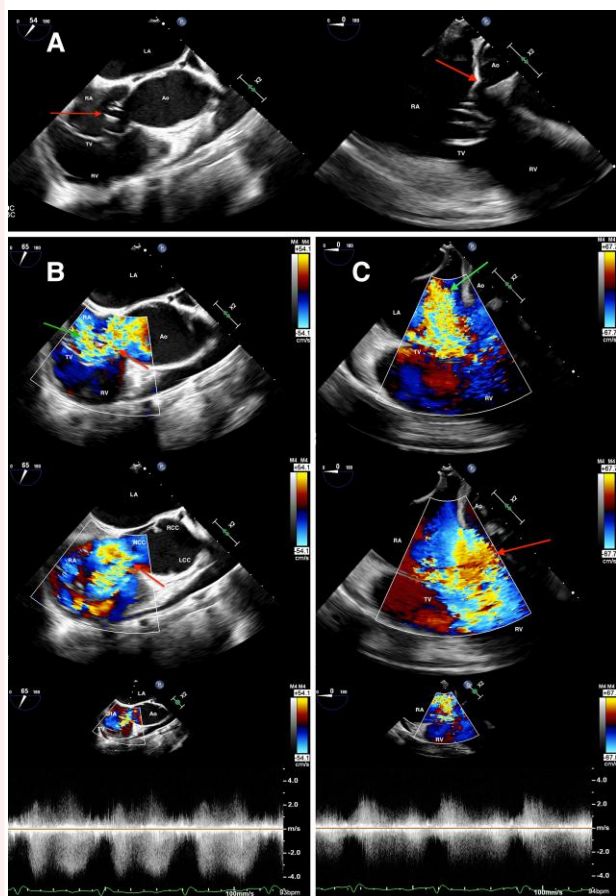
Transoesophageal echocardiographic images. Modified mid-oesophageal aortic valve short-axis view (A, left) and mid-oesophageal five-chamber view (A, right) revealing disruption of the aortic sinus and prolapse of the ‘windsock’ into the tricuspid valve. Modified mid-oesophageal aortic valve short-axis views (B) differentiating two individual systolic jets representing tricuspid regurgitation and ruptured sinus of Valsalva aneurysm flow (top), high-velocity diastolic ruptured sinus of Valsalva aneurysm flow (mid), and Doppler profile describing continuous flow through the ruptured sinus of Valsalva aneurysm (bottom). Mid-oesophageal five-chamber views (C) demonstrating moderate–severe systolic tricuspid regurgitation (top) and high-velocity diastolic ruptured sinus of Valsalva aneurysm flow through the TV (mid). Doppler profile demonstrates continuous forward flow and bidirectional systolic flow through the tricuspid valve (C, bottom). Red arrow, RSOVA and/or RSOVA flow; green arrow, TR. Other abbreviations as in [Figure 1](#) legend.
